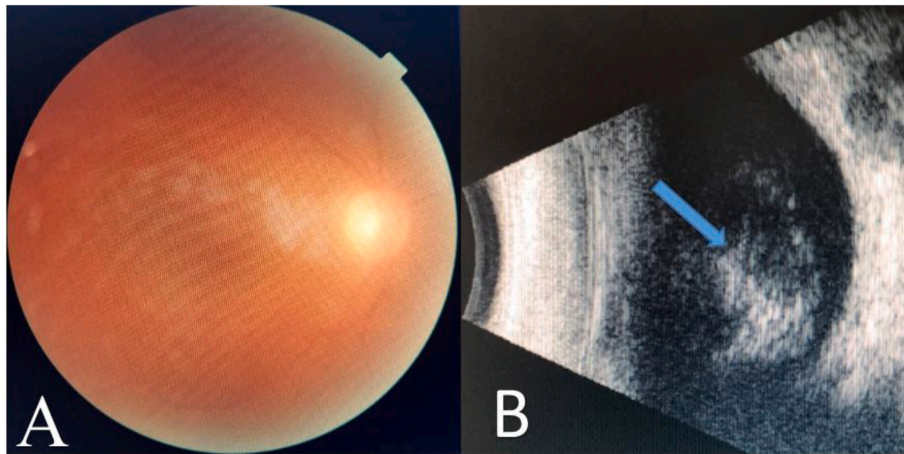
stage II intravitreal hemorrhage (A) and its appearance on B-mode ocular ultrasound showing dense, inferiorly organized intravitreal hemorrhage without retinal detachment (B).
